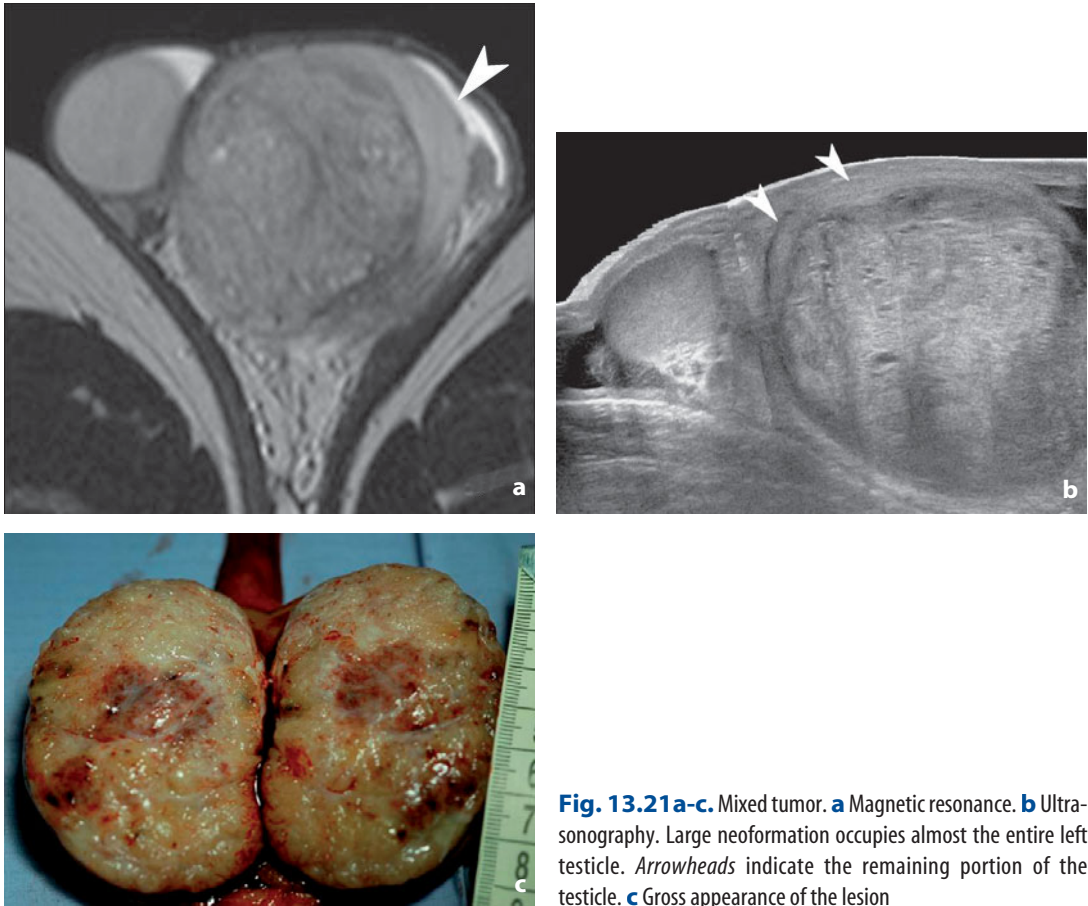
a-c. Mixed tumor. a Magnetic resonance. b Ultrasonography. Large neof ormation occupies almost the entire left testicle. *Arrowheads* indicate the remaining portion of the testicle. c Gross appearance of the lesion
